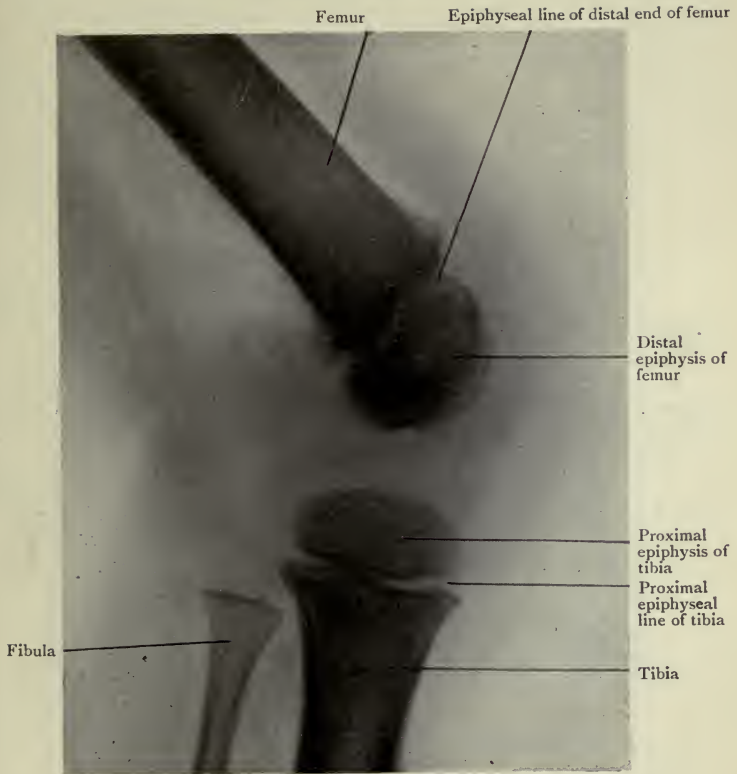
Radiograph of the Knee of a child.
